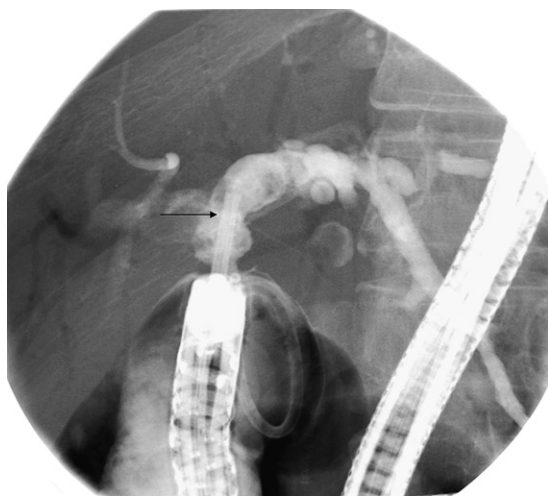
Radiograph taken at time of endoscopic retrograde cholangiography showing fragmentation of the stone. The cholangioscope can be seen exiting the tip of the colonoscope (arrow).
